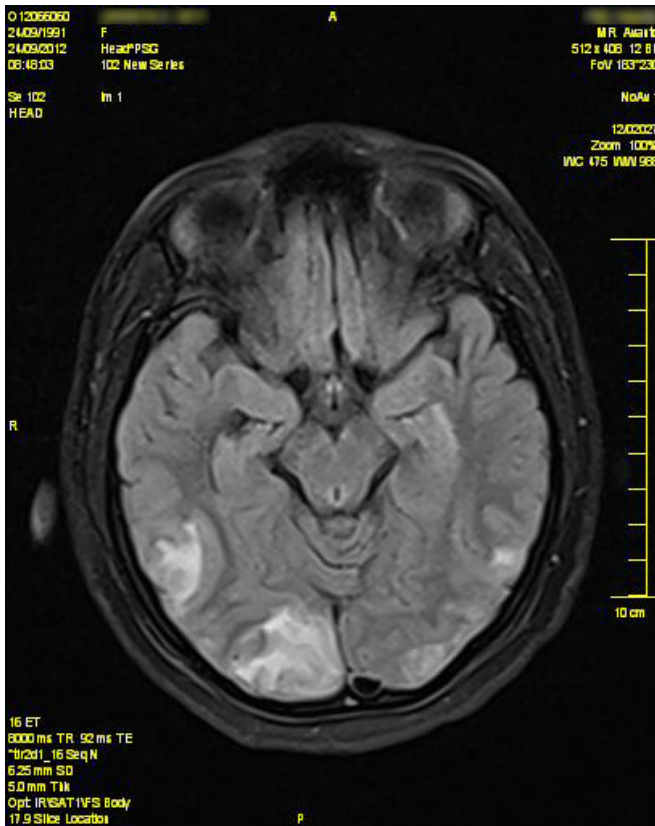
Axial MR image showing hyperintensities in bilateral occipital and posterior temporal lobes on FLAIR sequence suggestive of vasogenic edema
